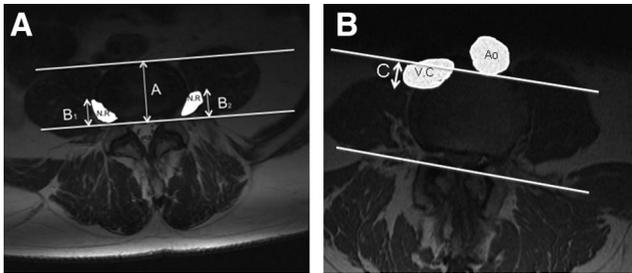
A, T2-weighted axial MR image at the level of the superior L4 endplate, the nerve roots are highlighted in white. Distance A is the AP diameter of the vertebral body. B1 and B2 are the distances between the ventral edge of the nerve root and the posterior edge of the vertebra. B, T1-weighted axial MR image at the level of the superior L3 endplate. Both the aorta (Ao) and *vena cava* (V.C) are highlighted. Distance C is the overlap between the ventral border of the vertebra and the *vena cava* posterior border.
